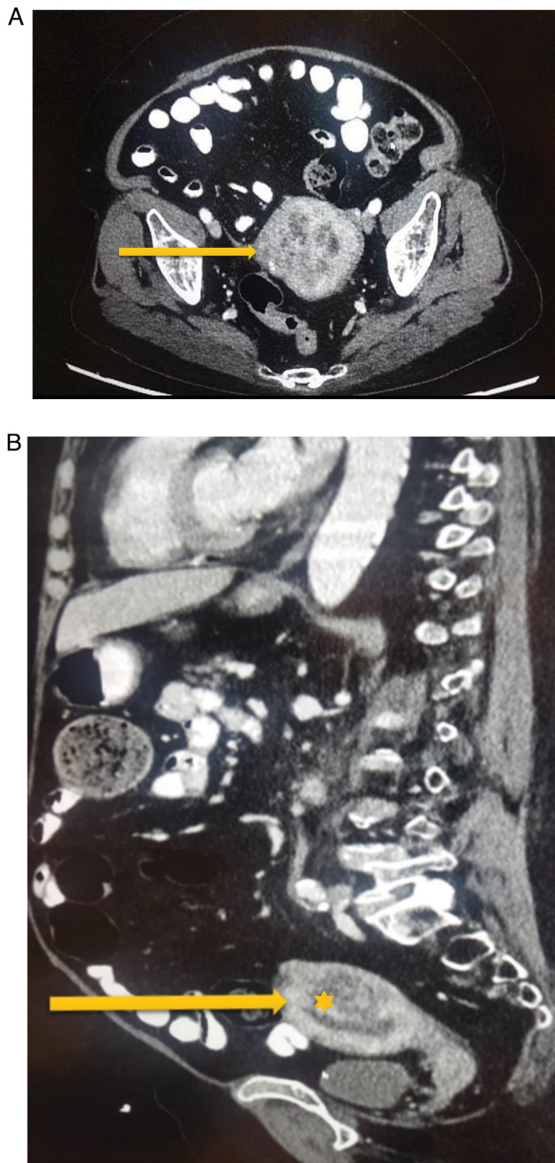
CT showing a heterogeneous lesion occupying the posterior wall of the uterus, compressing the endometrial cavity. (A) Sagittal view. (B) Cross-sectional view of the uterus. The arrows point to the uterus and the star indicates the thick endometrium previously measured by ultrasound at 8 mm.
